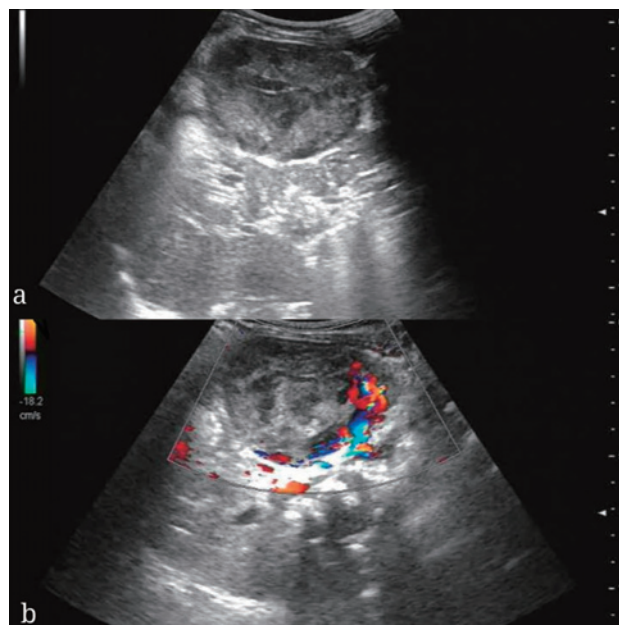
(a, b) Ultrasonography detection showed a well-defined solid mass in the left kidney with partial cystic degeneration and bulky blood vessels.
